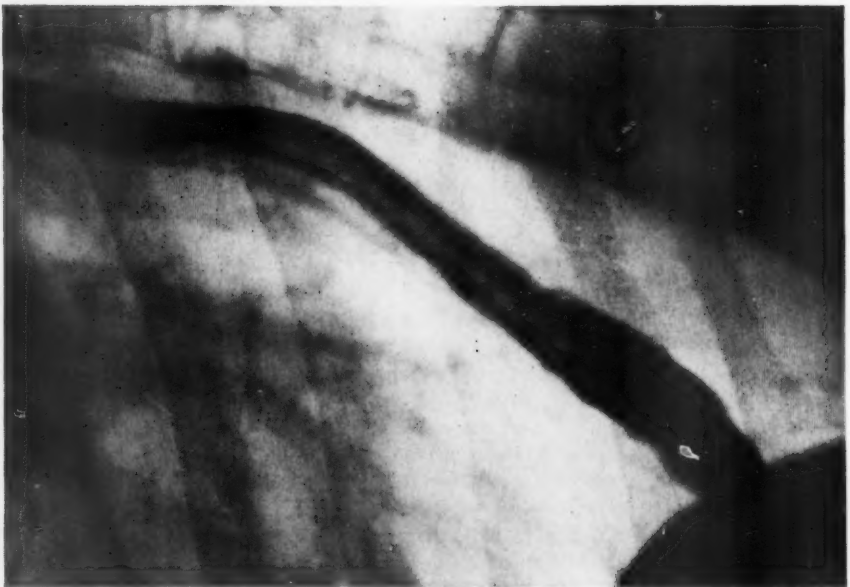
Case 2: Roentgenogram showing esophageal varices.
